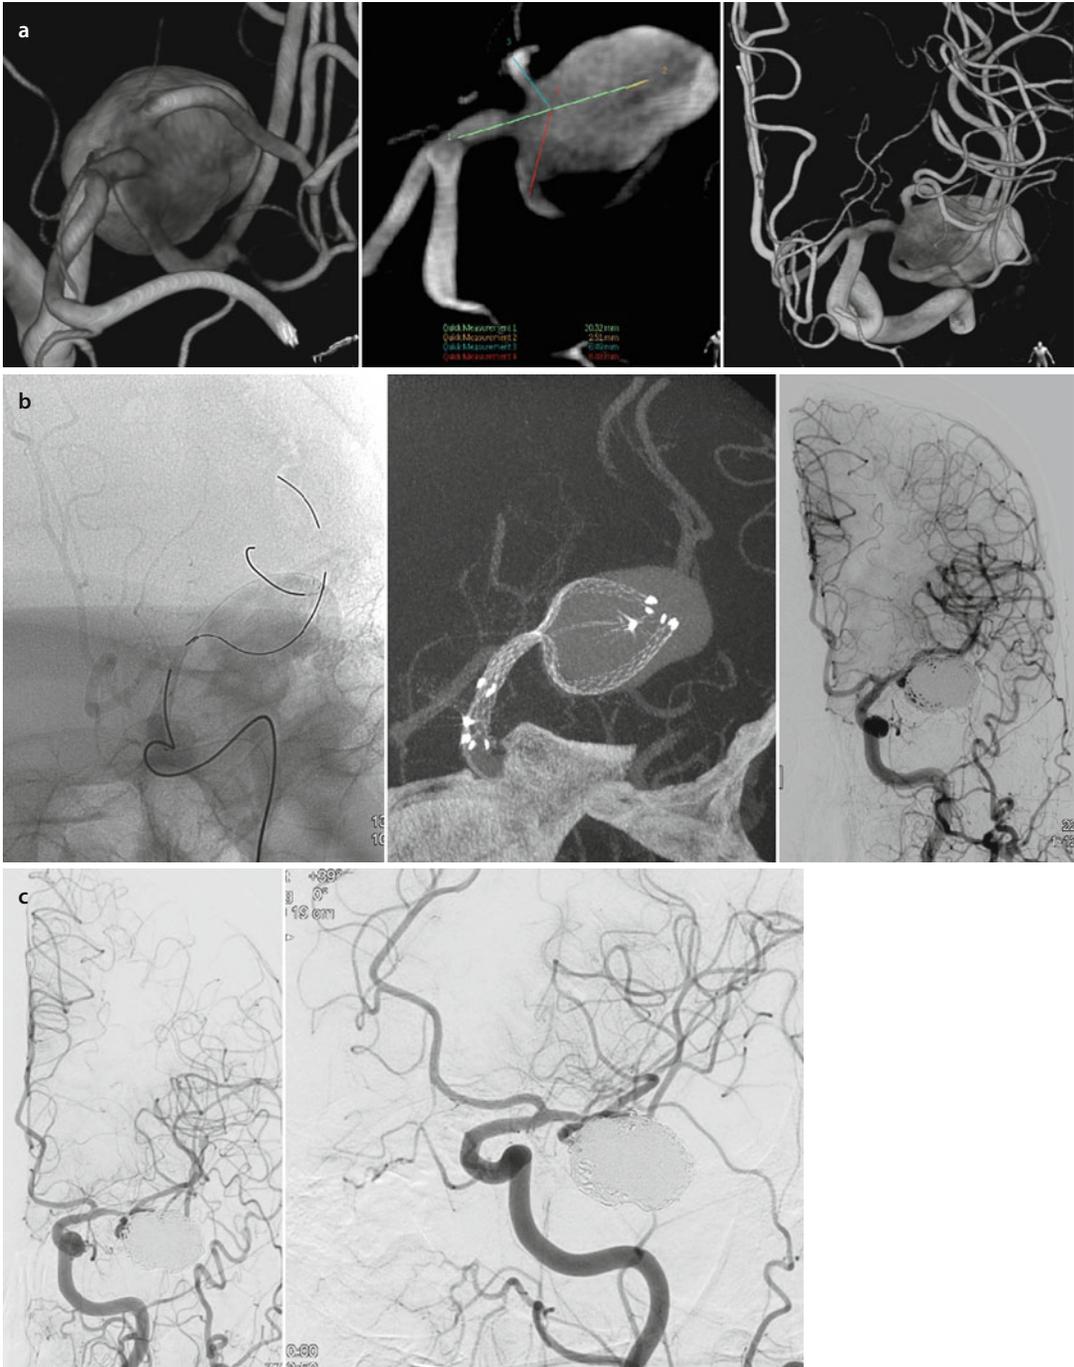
A 60-year-old man planned for cardiac surgery presented with headaches. (a) Cerebral DSA reveals a 25 × 17 mm-sized left MCA bifurcation GIA. The aneurysm involves the origin and proximal portions of both the upper and lower divisions of MCA. The upper division arises at an acute angle (57°), whereas the lower division arises at a right angle (90°). (b) A buddy wire was navigated into the upper division to change the acute angle to an obtuse angle. Subsequently, the stent delivery system was navigated into the lower division. After deployment of the stent in the lower division, another stent was deployed in the upper division across the bifurcation aneurysm. Post-stenting; VASO CT® images reveal Y-stent configuration and the final changed angle of MCA bifurcation. Immediate post-stenting and coiling images reveal near-complete occlusion of MCA bifurcation aneurysm. (c) On 2-year follow-up, there was mild neck recanalization but otherwise stable aneurysm occlusion
